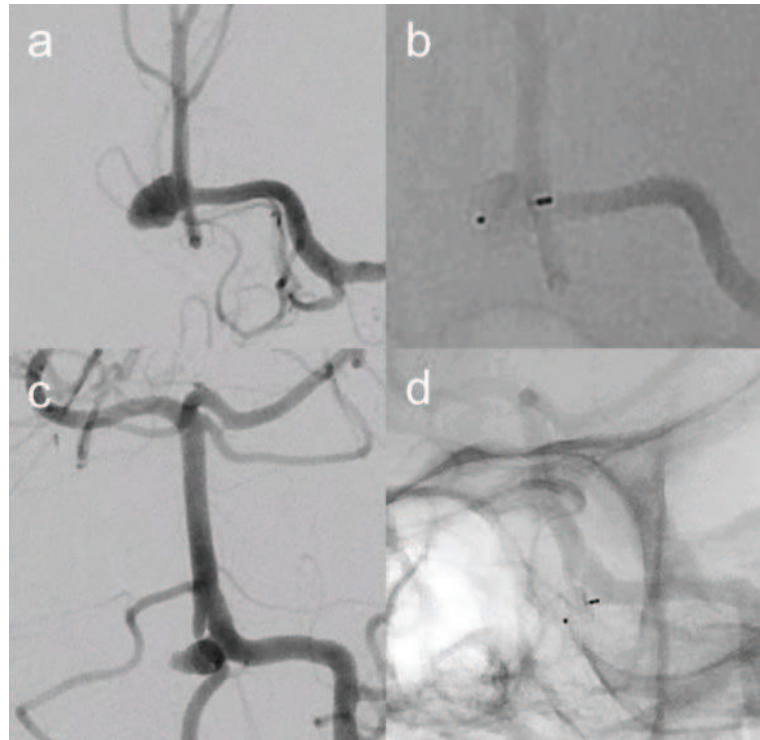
Embolization of a basilar tip aneurysm with the Contour device. Angiogram in oblique projection before treatment (a). Unsubtracted image demonstrating decreased filling of the aneurysm after device detachment (b). Flat-panel CT showing optimal wall apposition and neck coverage (c).
